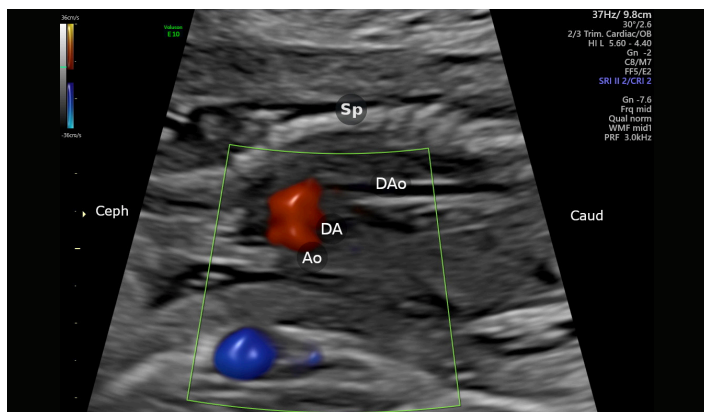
Sagittal view of the aortic and ductal arches using traditional colour Doppler.
